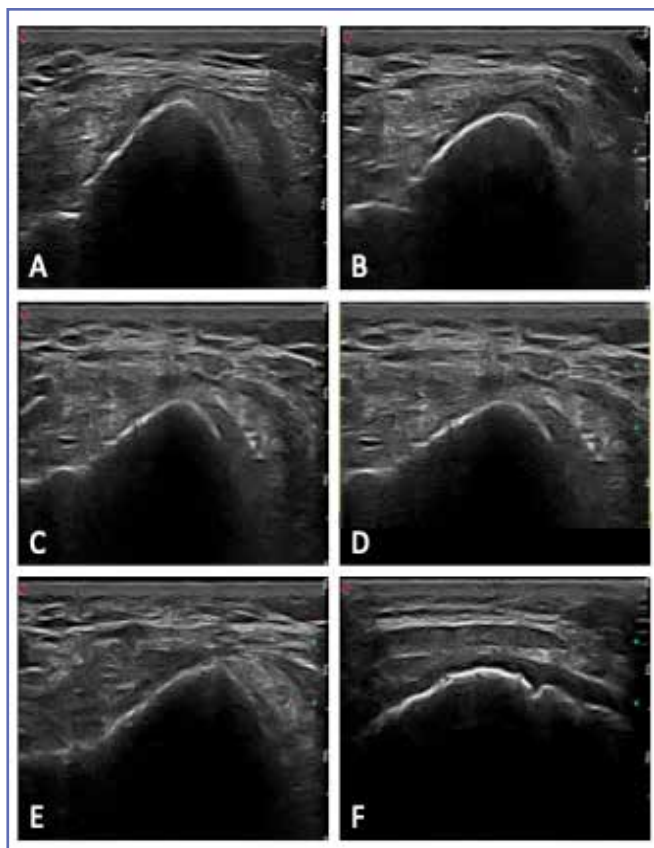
Representative ultrasonographs of lateral femoral cartilage changes. Ultrasonographs of the lateral femoral cartilage from three patients at baseline and 12 months follow-up are shown in A-B, C-D and E-F, respectively.
